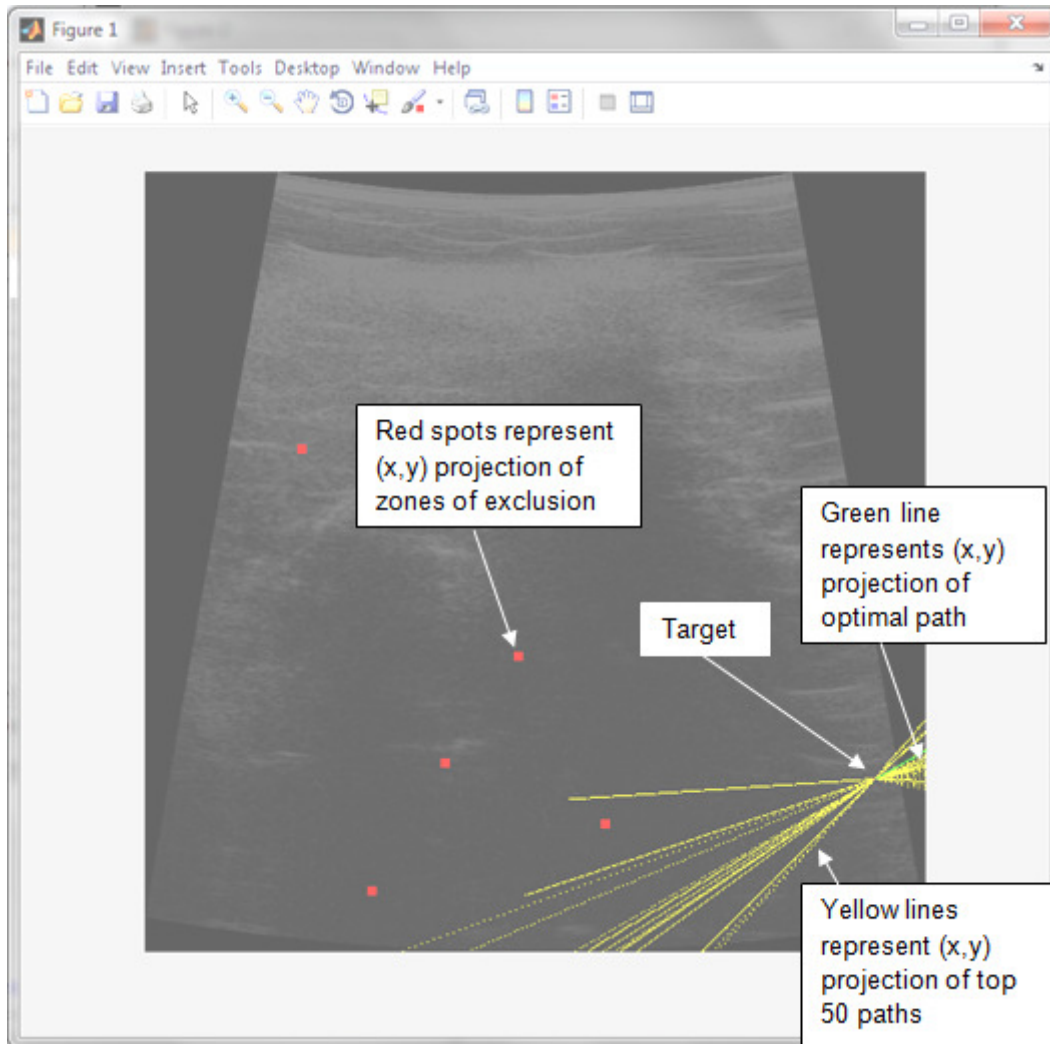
2D projections onto first Ultrasound slice for global minimum path
